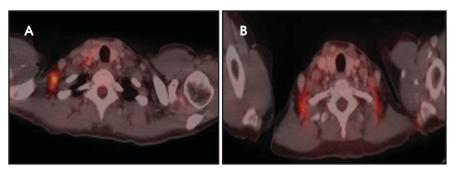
FDG-PET/CT (A) showing 1.6-cm hypermetabolic posterior-lateral supraclavicular lymph node with complete metabolic response (B) on postneoadjuvant chemotherapy FDG-PET/CT (incidentally noted symmetric posterior FDG avidity from brown fat).
